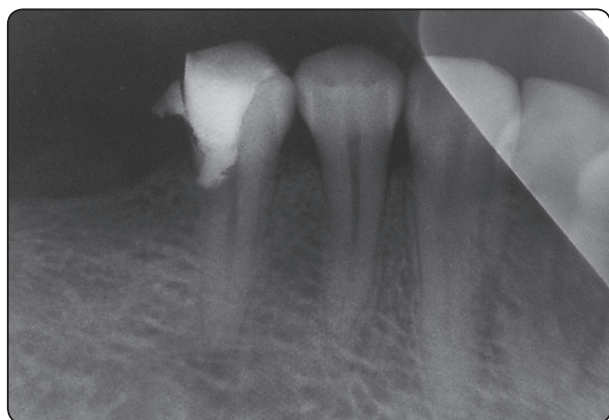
A radiograph of the same tooth using placental extract as a regenerative approach (after two years).
